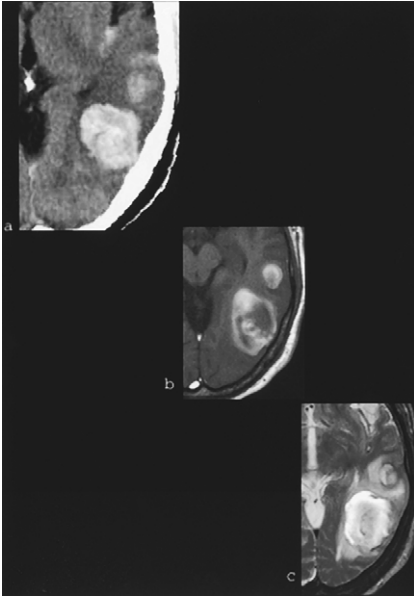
Transverse sinus thrombosis. (a) Acute lobar hematoma on CT in the left temporal lobe (a). T1-weighted image (b) and T2-weighted image (T2WI) (c) obtained 8 days after ictus demonstrate high signal at the periphery of the hematoma caused by extracellular methemoglobin. Note the thin dark rim on the T2WI, which reflects hemosiderin.
